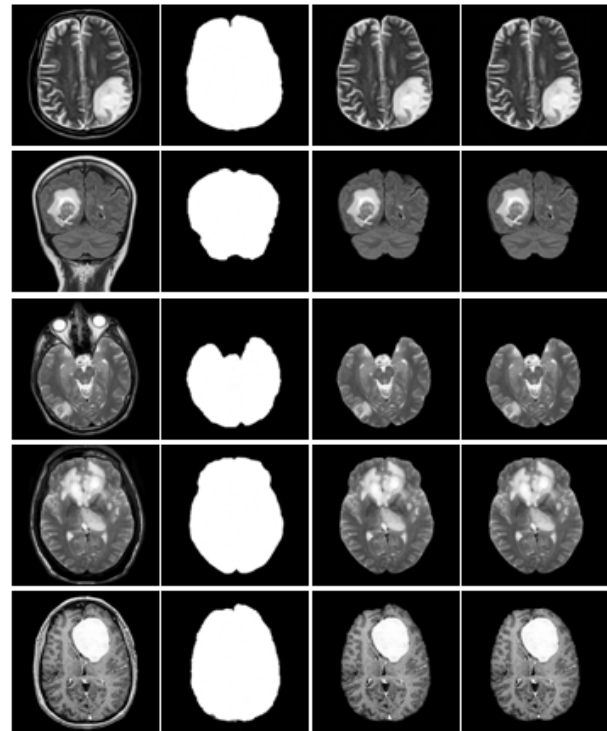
Segmented brain nuclei of abnormal brain MR images: a) Input brain MRI, b) Brain mask, c) Segmented brain nuclei by proposed method and d) Segmented brain nuclei by BSE.
